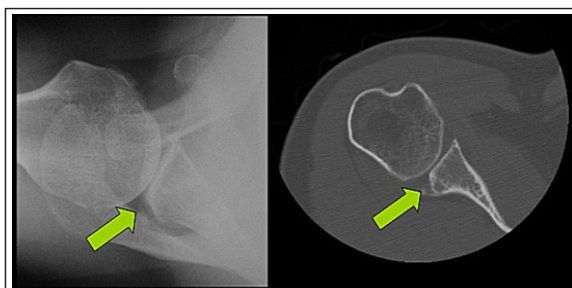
(a) X-ray of reverse bony Bankart lesion, (b) lesion seen on computed tomography.
